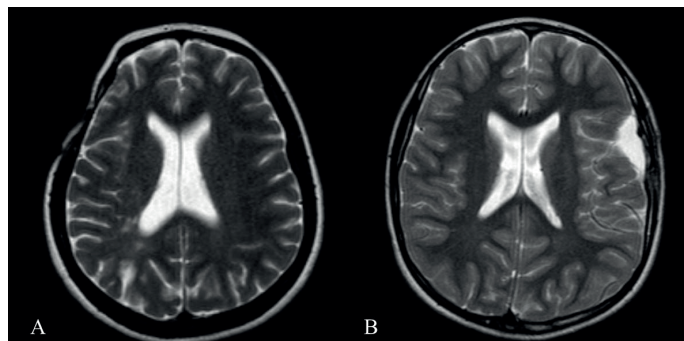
T2-weighted magnetic resonance images of patient number 1 and 3. In both, there was no obvious abscess formation in the intracranial region
